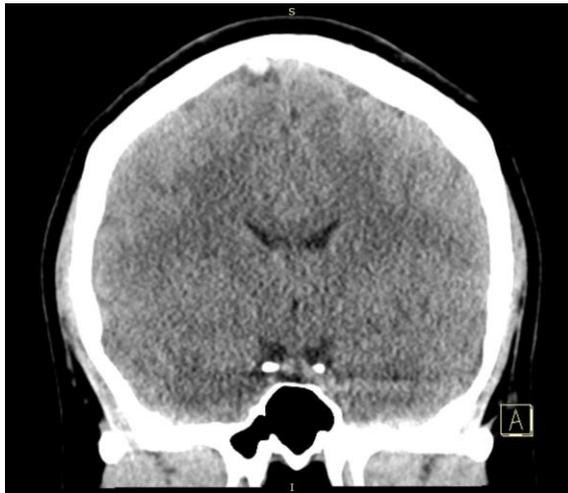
Coronal CT w/ Superior Sagittal Sinus Thrombosis
